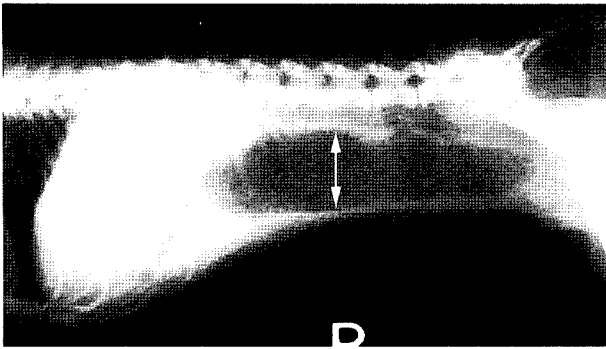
A lateral view of abdominal radiographs. The diameter of the bowel was severely enlarged approximately 3 or 4 times the height of body of lumbar vertebra (double arrow).
